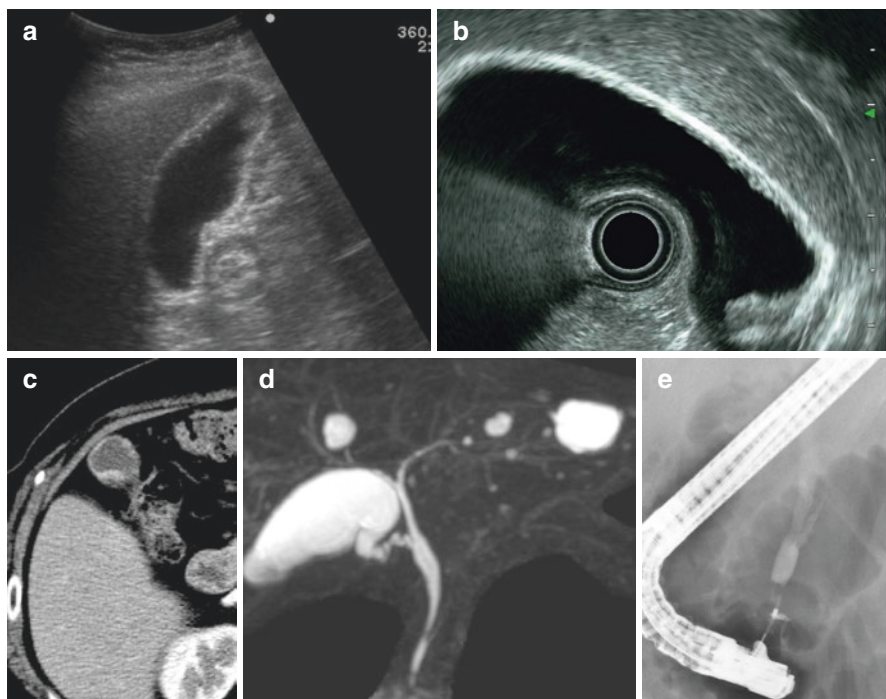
A case of PBM without dilatation of the common bile duct (51 years old, female). The gallbladder wall thickening in the inner layer was detected in US (a) and EUS (b). Enhanced CT demonstrated the gallbladder wall thickening (c). MRCP suspected the presence of PBM (d). Finally, ERCP demonstrated the PBM without dilatation of the common bile duct (e)
